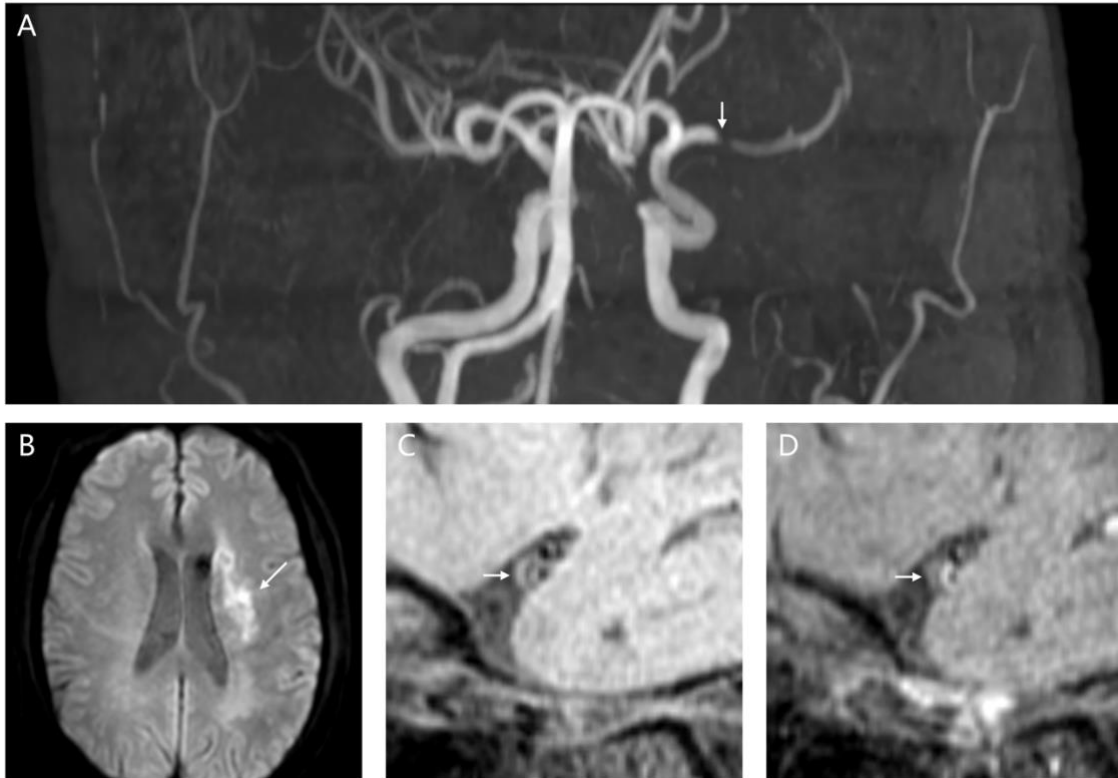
A 68-year-old male patient with acute infarction in the left anterior circulation. A, a symptomatic atherosclerotic stenosis of the left MCA-M1 on MRA imaging (white arrow). B, acute infarction in the left MCA-M1 territory on DWI (white arrow). C and D, an eccentric, focal plaque in the left MCA-M1 as a symptomatic atherosclerotic lesion before and after administering contrast on T1w imaging, respectively (white arrows). DWI, diffusion-weighted imaging; MCA, middle cerebral artery; MRA, magnetic resonance angiography; T1w, T1-weighted.
